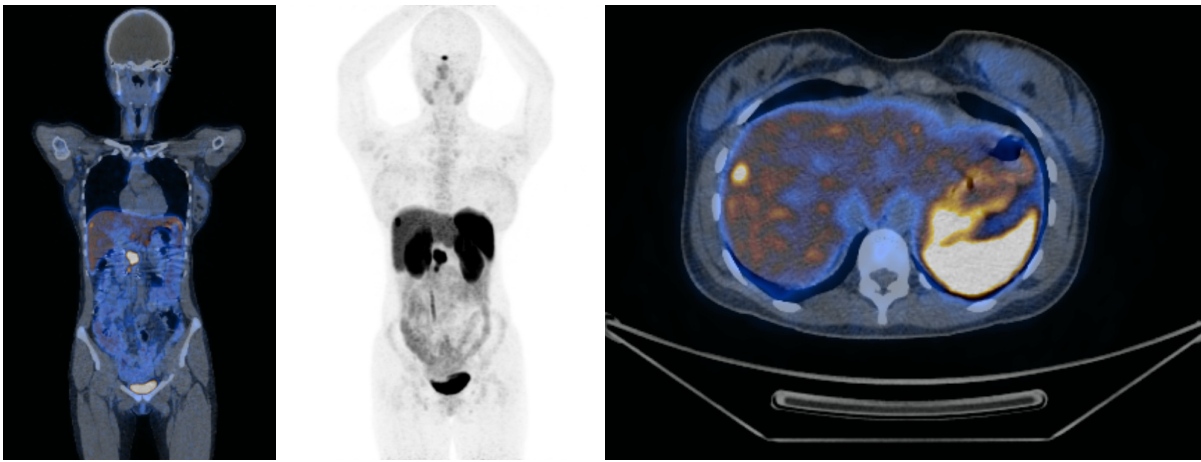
[^{68}Ga]Ga-DOTA-TATE PET/CT — February 2021 — pathological SSTR expression in pancreatic head tumour and in liver metastases (segment VII/VIII and V)
